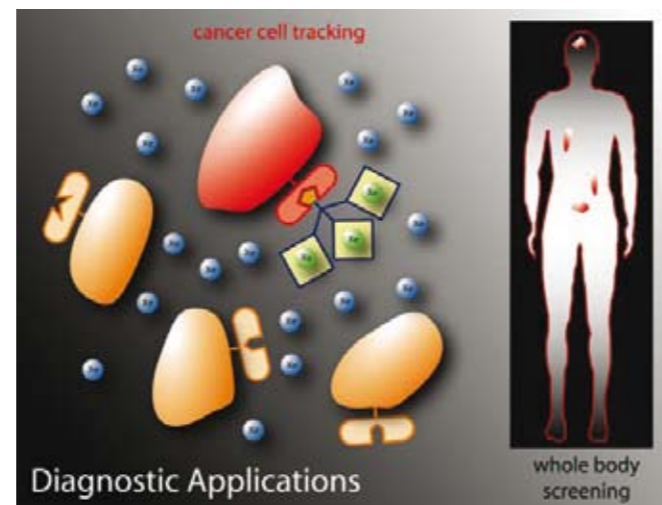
Potential applications of xenon biosensor MRI range from *in vitro* cell tracking to whole body screening in cancer diagnostic. The next sensor generation will be more sensitive due to "chemical amplification", using several molecular cages per sensor to encode the xenon signal.
